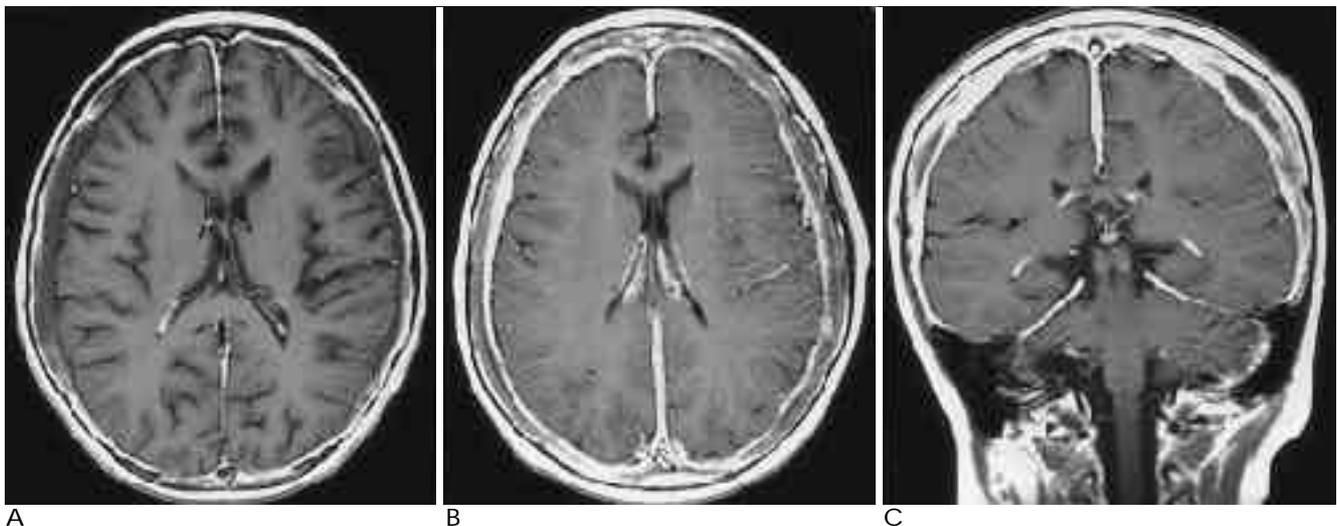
Postoperative benign meningeal enhancement. Enhanced T1-weighted axial MR image (A) obtained 2 months following surgery reveals slightly thickened, wavy and generalized dural enhancement along the margin of subdural fluid collections. Enhanced T1-weighted axial (B) and coronal images (C) obtained 1 year later show persistent bilateral subdural fluid collections with increasing dural thickening and enhancement. Irregular peripheral enhancement of the fluid collection is seen, suggesting organizing phase of the fluid collection. The child was clinically well.
